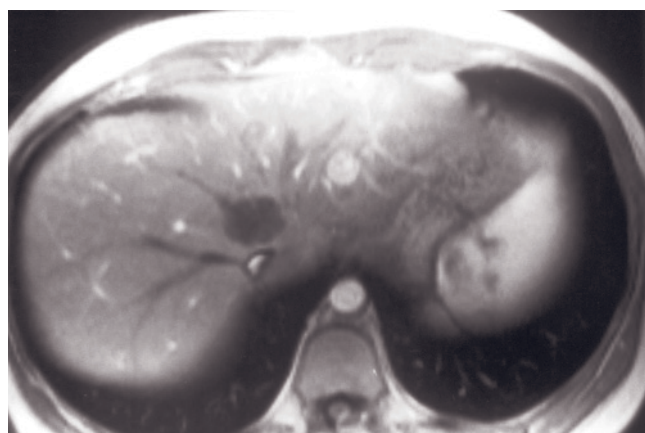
(Continued) high signal intensity on the T2-weighted image (arrow, *a*), low signal intensity on T1-weighted image (*b*), a lack of enhancement on early image (*c*) and peripheral globular enhancement on late image (*d*) compatible with a slow-enhancing hemangioma. Slow enhancement is a feature that suggests the diagnosis of a hemangioma.
